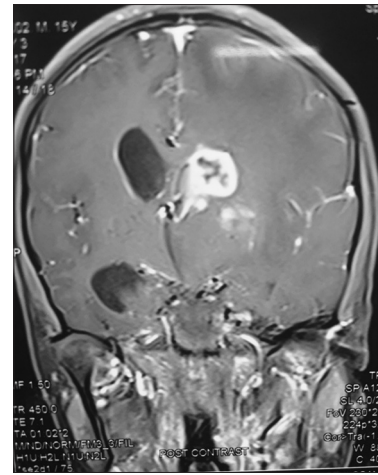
Magnetic resonance imaging brain with contrast showing conglomerate ring enhancing lesion
